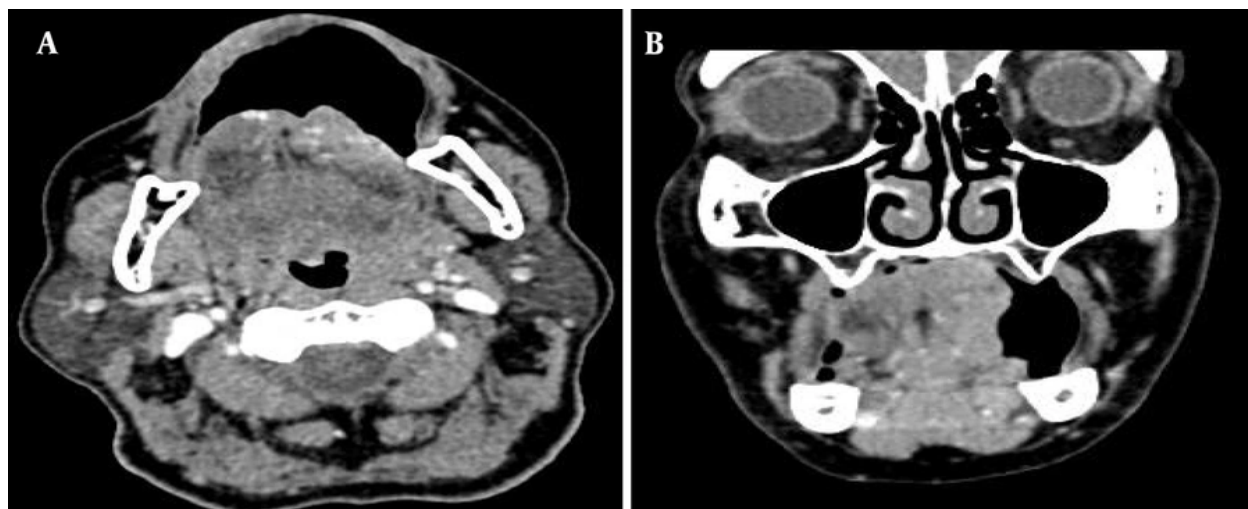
The puffed-cheek technique was used in this patient with left lateral tongue squamous cell carcinoma to separate the buccal mucosa and improve visualization of the tumor surface, as shown in the axial (A) and coronal (B) planes of contrast-enhanced CT.
